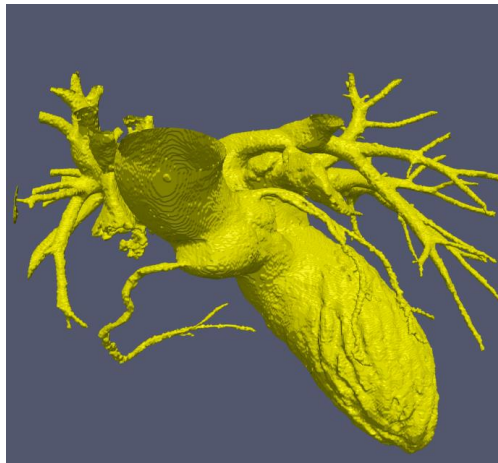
CTA volume data segmentation after denoising.
